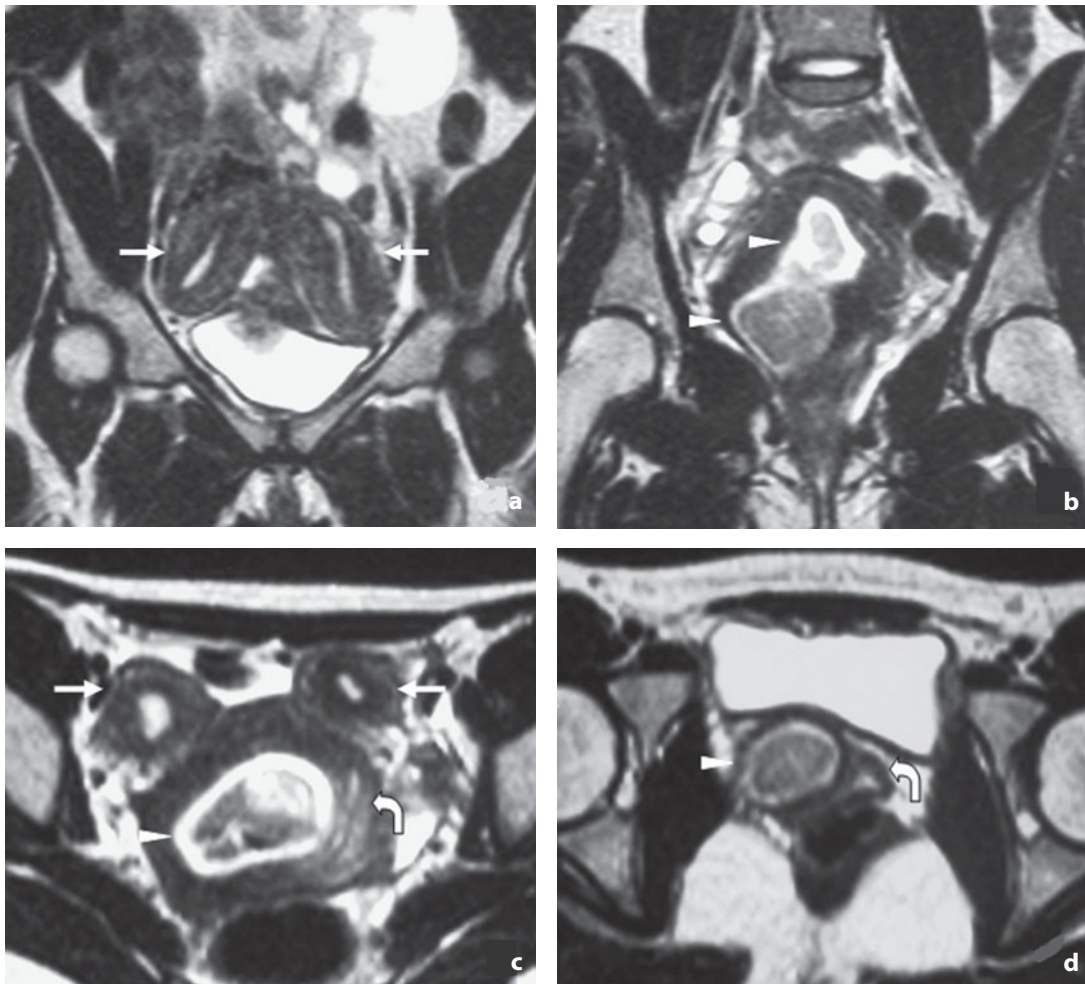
Didelphic uterus with obstructed hemivagina. The coronal (a,b) and axial (c,d) T2-weighted magnetic resonance images show two separate and diverging uterine cavities with hyperintense endometrium and hypointense myometrium (*arrows*). The right hemivagina dilated by heterogeneously hypointense fluid is discernible, surrounded by a hyperintense ring formed by blood material in various stages of development (*arrowheads*). The left hemivagina shows no signs of obstruction (*curved arrow*)
